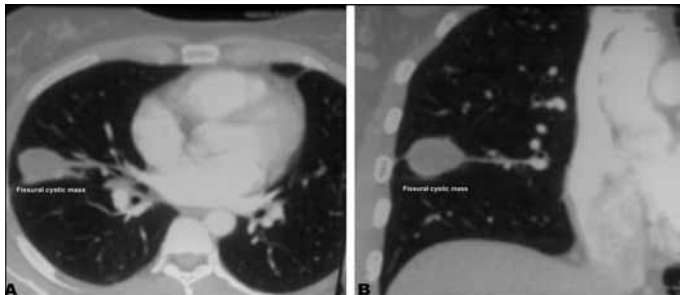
The thoracic CT appearance of a fissural cyst (A). Cystic lesion was located at right major fissure (B).
